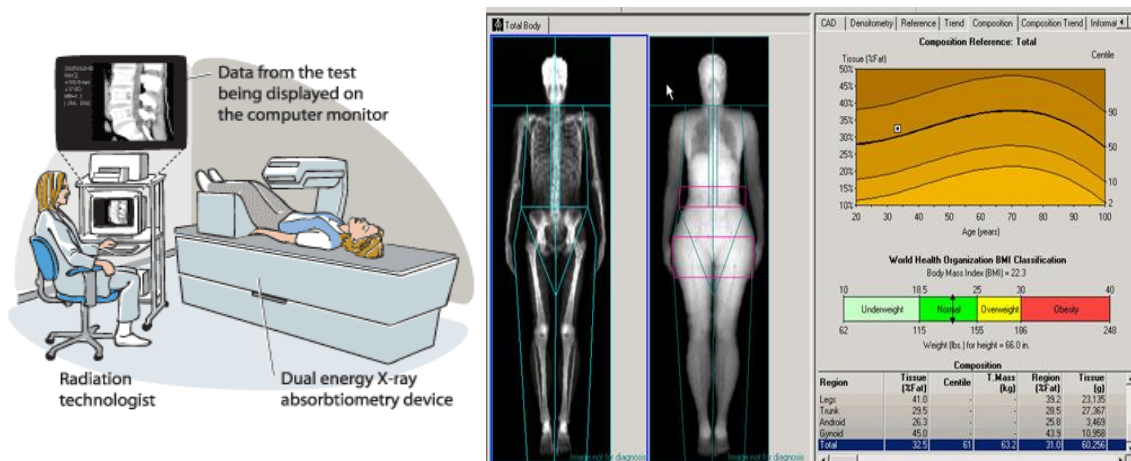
Dual-energy X-ray absorptiometry (DXA) [11].
